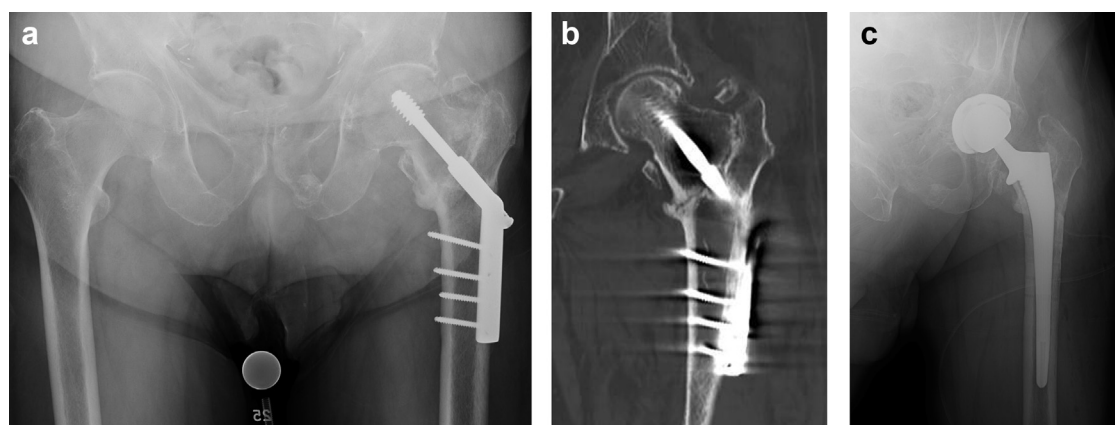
(a) Preoperative sliding hip screw device in place with intertrochanteric nonunion, significant hypertrophic bone, and altered proximal femoral anatomy (anteroposterior radiograph). (b) Preoperative CT image revealing intertrochanteric fracture nonunion (coronal image). (c) Postoperative radiograph after conversion to total hip arthroplasty (anteroposterior radiograph).
